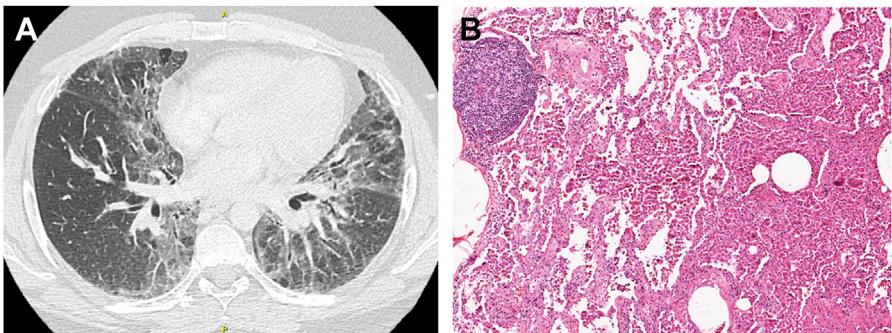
DIP. (A) Axial CT image showing bilateral ground-glass opacities along with some reticular opacities and few regions of hyperlucency (air-trapping). (B) Diffuse accumulation of pigmented alveolar macrophages with mild interstitial thickening due to fibrosis. Lymphoid follicles with a prominent germinal center (shown in the upper left field) are often present in DIP.
